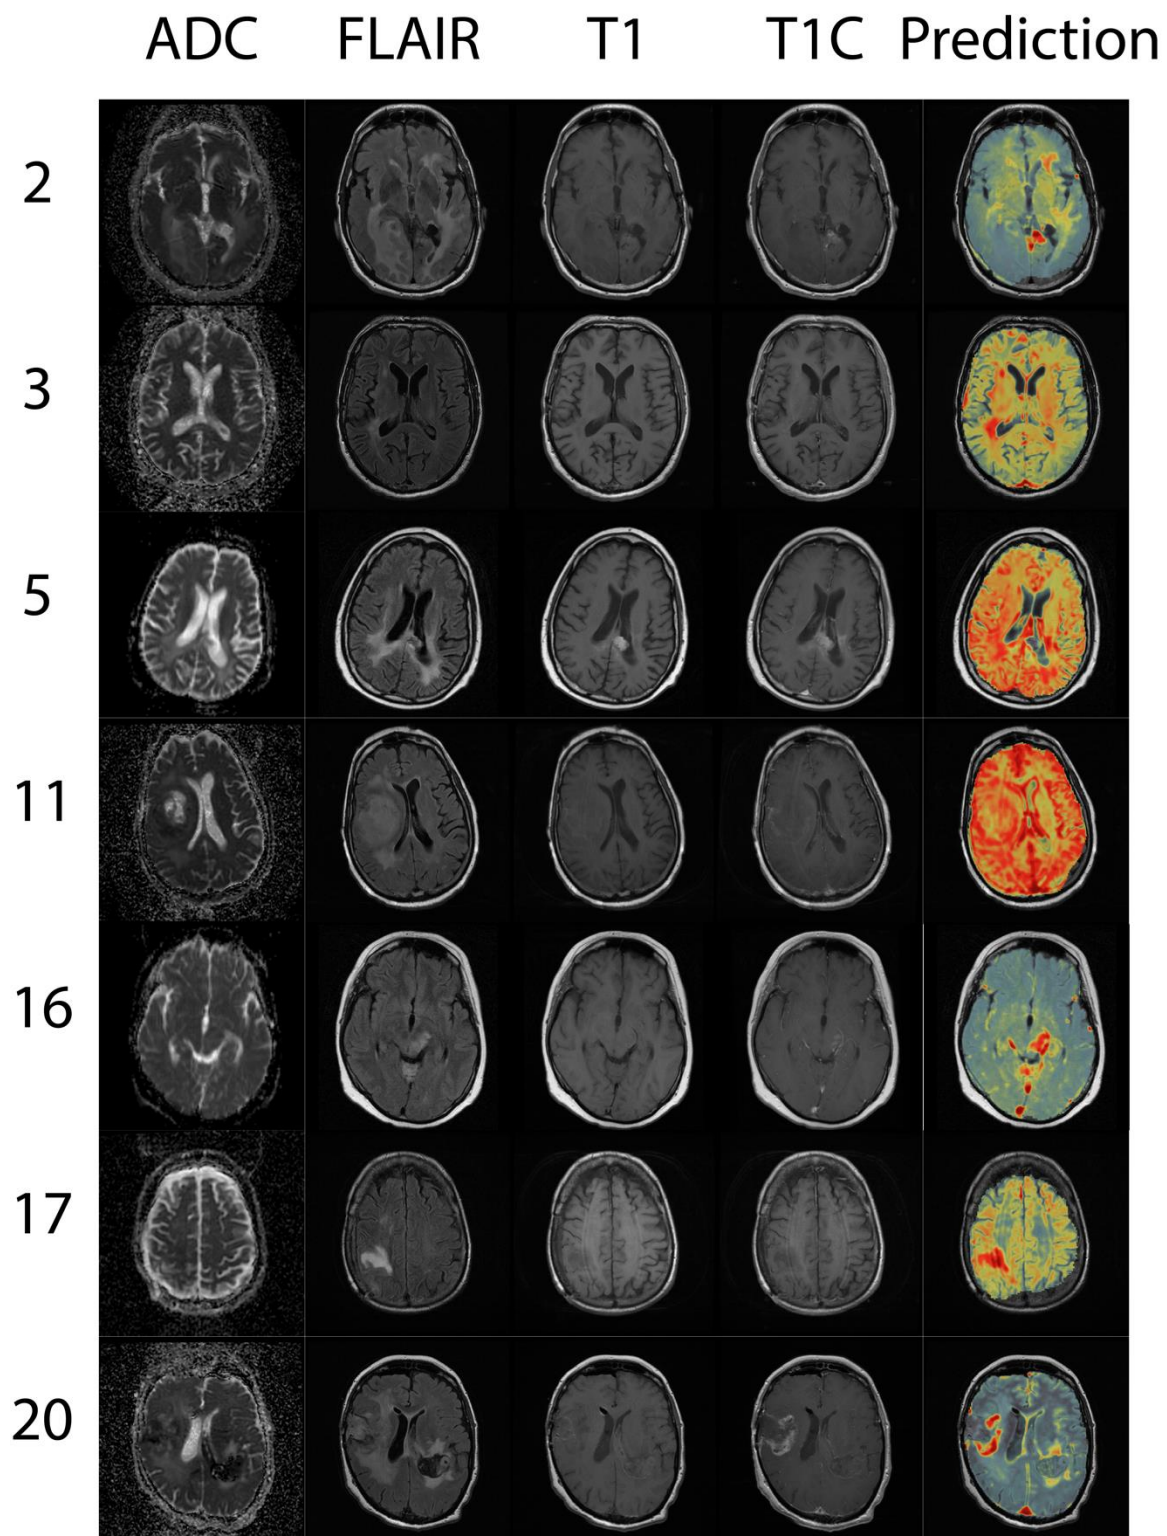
A representative MRI slice from each of the test set subjects from the MRI portion of this study.
